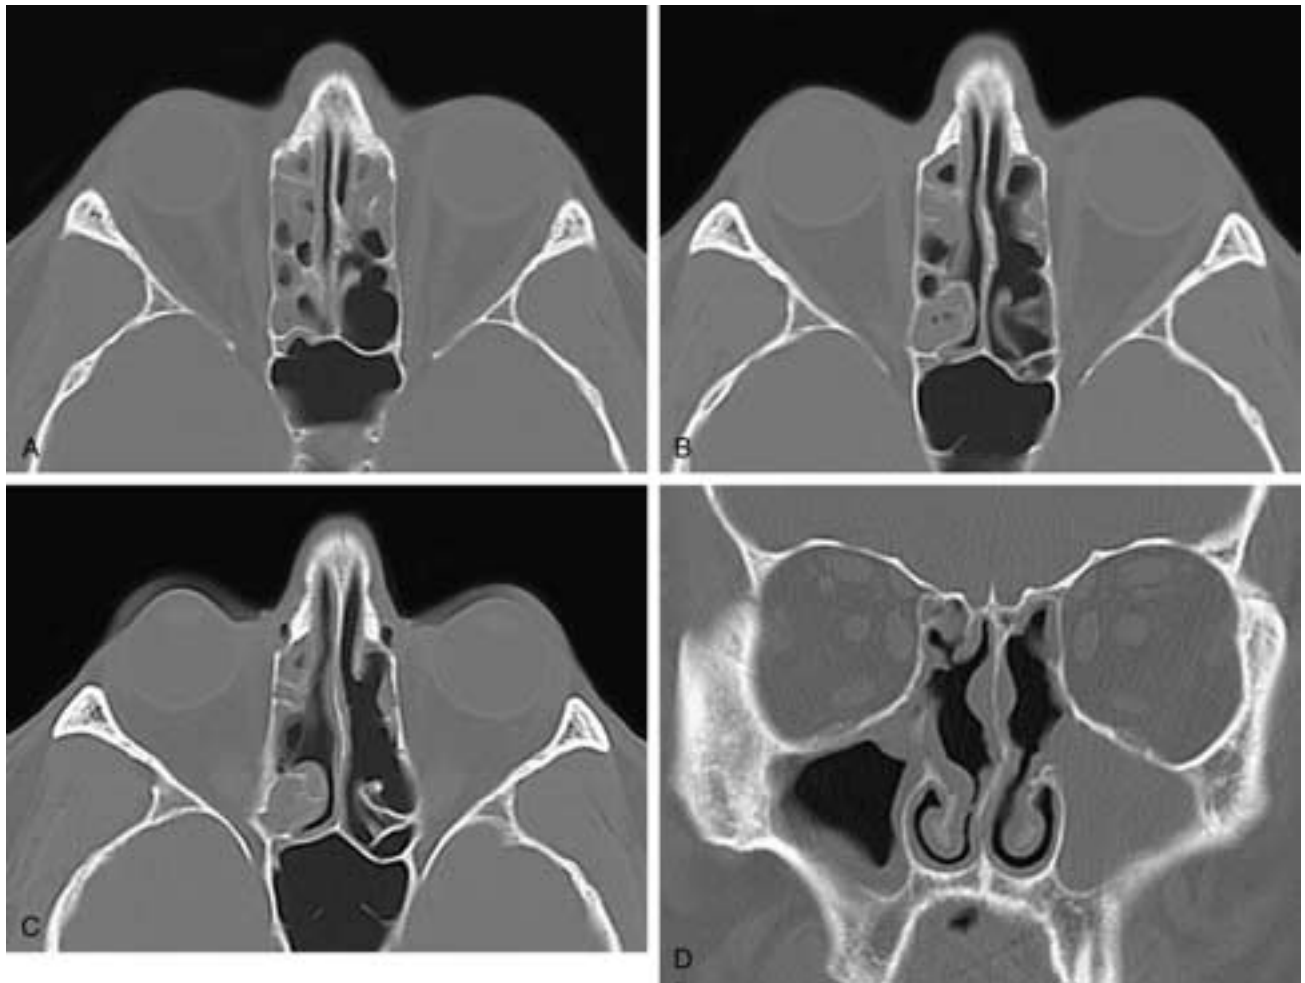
Serial axial CT scans from cranial (A) to caudal (C) and a coronal CT scan (D) on this patient who has had bilateral internal ethmoidectomies. The most superior cells remain anteriorly on both sides. The upper middle and posterior cells are also still present on the right side. Inflammatory disease is present in these remaining cells. Typically, the upper and posterior cells are not removed in internal ethmoidectomies because the surgeon does not want to enter the anterior cranial fossa inadvertently. The middle turbinates were removed at surgery, and inflammatory disease is present in both maxillary sinuses.
